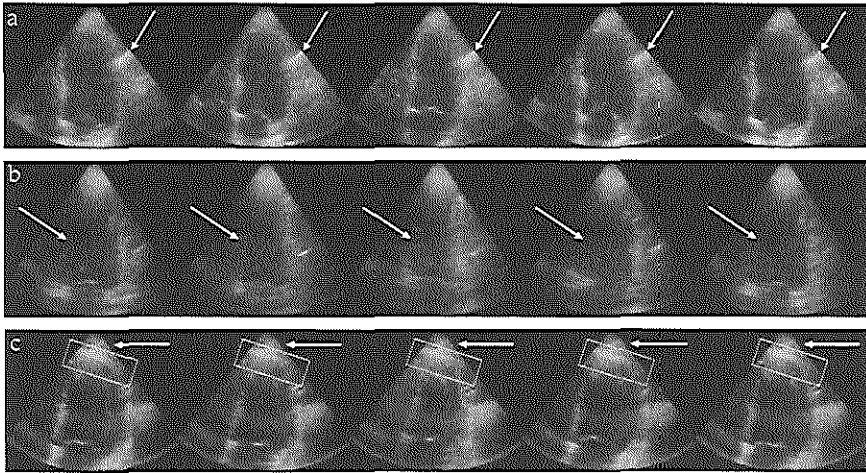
Typical artifacts in echocardiographic sequences. (a) Side-lobe artifact. (b) Shadowing, obscuring the myocardial wall. (c) Near-field clutter close to the transducer, in this case more pronounced probably due to a rib echo (arrow); the edge in the dotted box is not part of the left ventricular apex but an artifact which does not move throughout the sequence.
